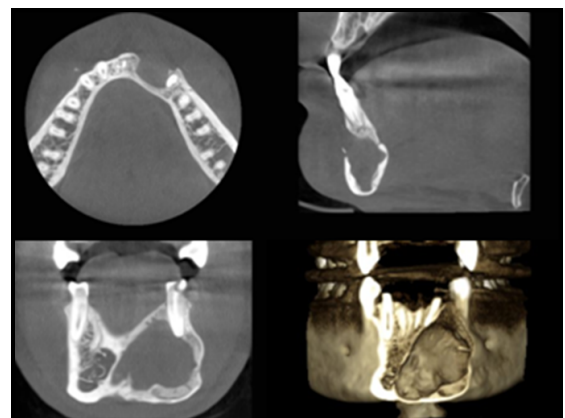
Post-operative CBCT scan
